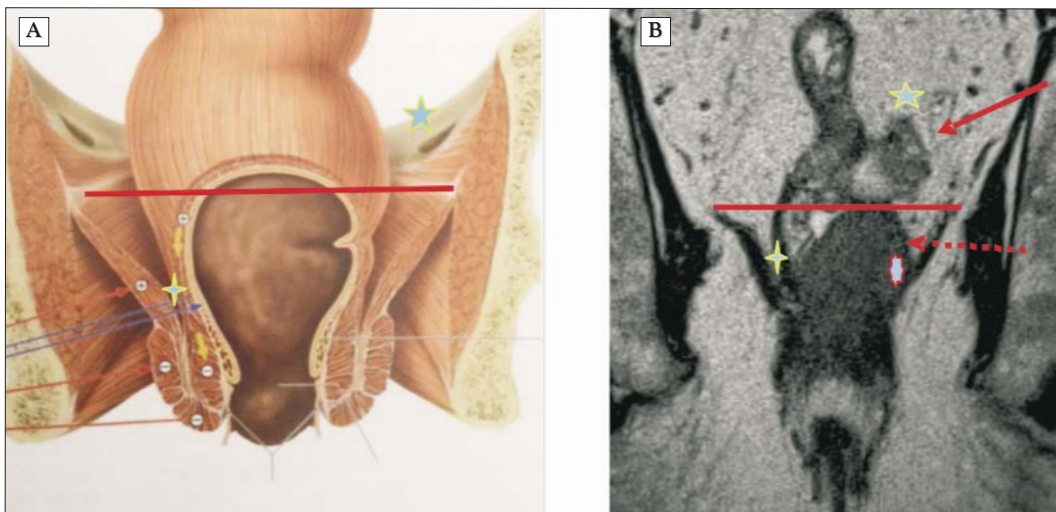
Low rectal cancer with CRM+ infra- and supra-levator. (A) Anatomy. (B) T2 paracoronal corresponding to the anatomical preparation. We can observe the invasion of the mesorectum (star) in 2-3 o'clock position, the unsafe mesorectal fascia (red arrow) and the invasion of the intersphincteric plane at 5 o'clock (interrupted arrow, red star), so both planes are unsafe. Preoperative radiochemotherapy is recommended. If the treatment is successful resulting in the restaging at MRI, this will be followed by TME.
